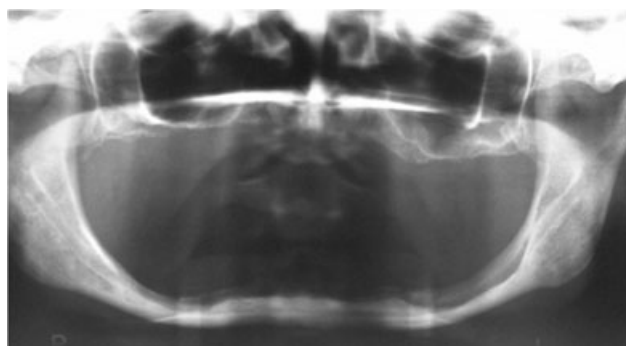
Presurgical orthopantomograph.
